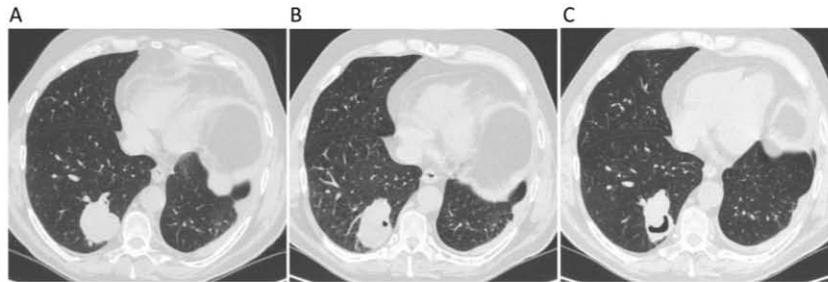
A–C. Patient 7. A) Chest CT scan shows a mass at the cancer diagnosis (May 2010). B) At *Aspergillus* spp. detection (October 2010), a cavitation is seen in the mass. C) Progression of the cavitation after *Aspergillus* spp. isolation (March 2011).
